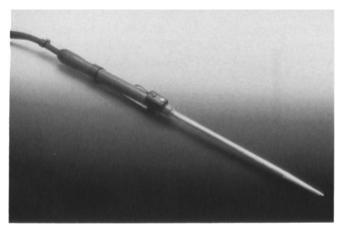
The Valleylab CUSA Laparoscopic Accessory with the CEM (CUSA Electrosurgery Model) provides ultrasonic dissection, electrosurgery, suction, and irrigation in one 10-mm laparoscopic unit.
